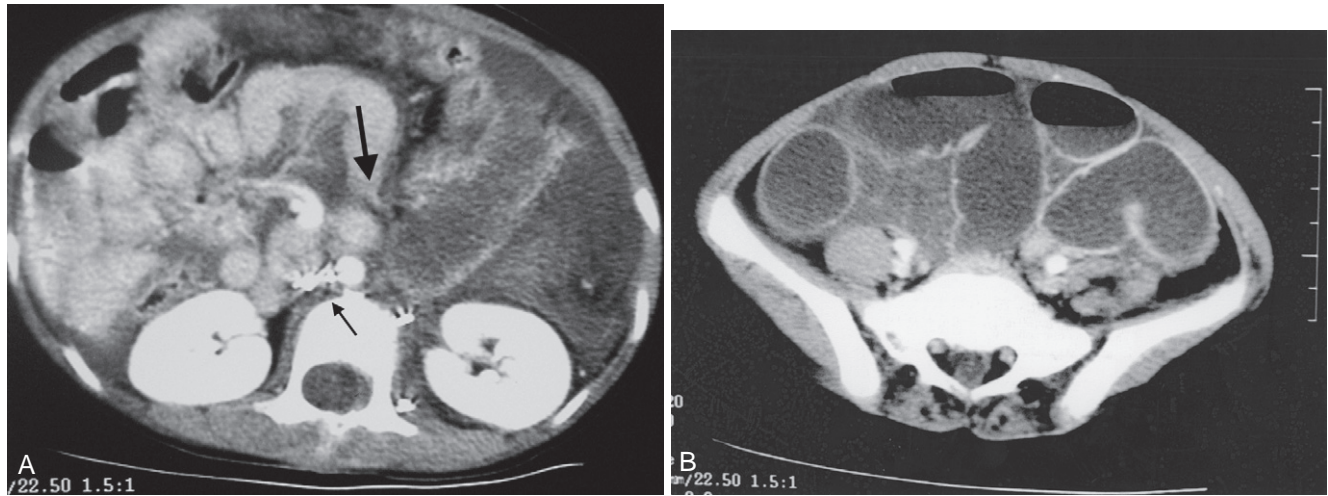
Incomplete small bowel obstruction. A, Contrast computed tomography (CT) scan of child with a partial small bowel obstruction after resection of a ganglioneuroma. The *small arrowhead* points to surgical clips from the previous resection. The *large arrowhead* demonstrates the transition zone of the obstruction. Note the dilution effect of the contrast in the dilated bowel. Partial obstruction is noted with passage of contrast past the transition point. B, Contrast CT scan from the same patient demonstrating proximal dilated fluid-filled bowel loops in the pelvis with air-fluid levels present.
